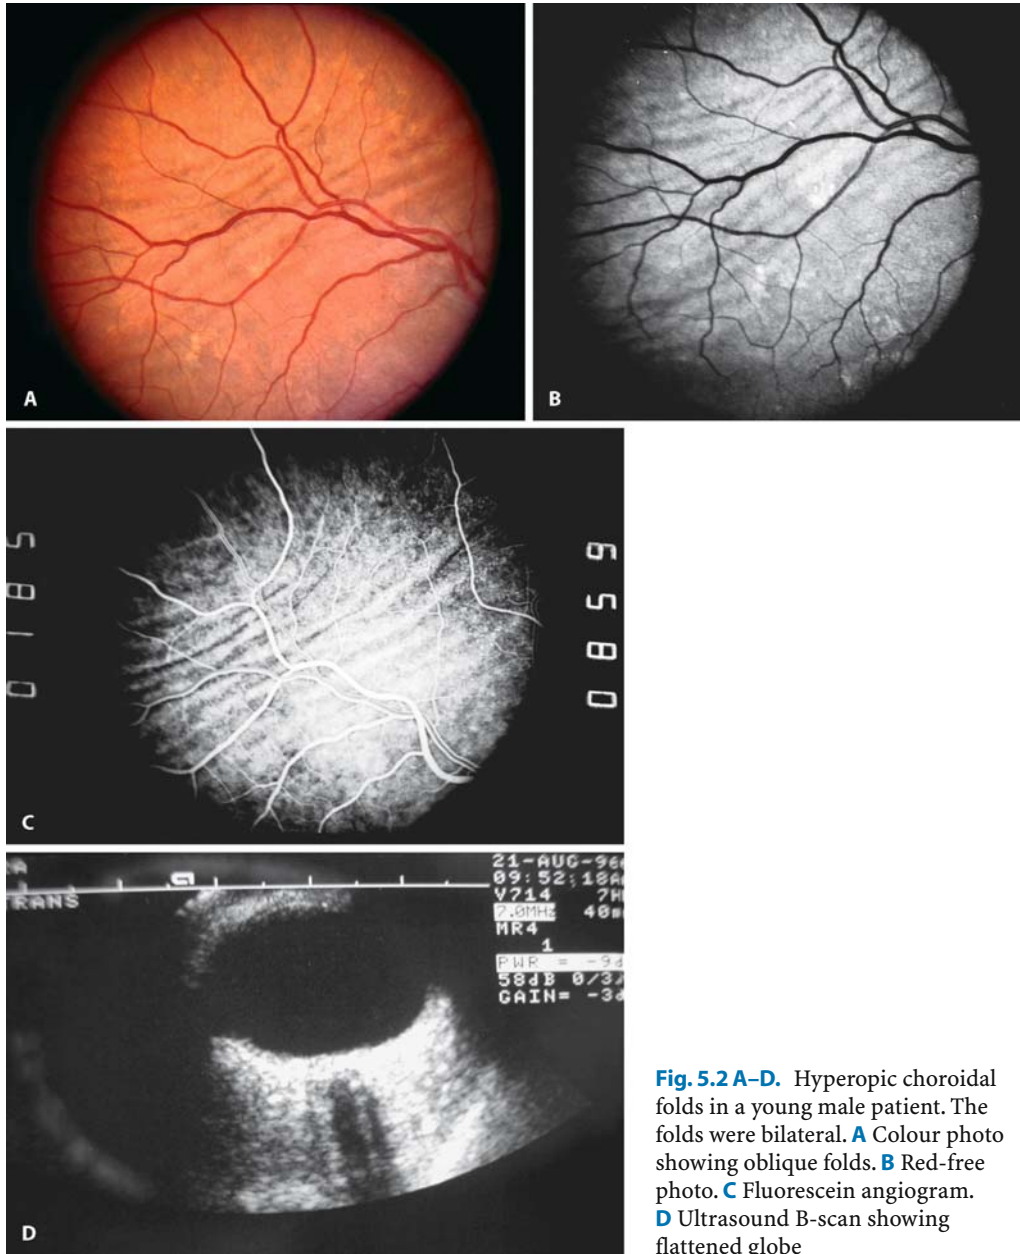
A–D. Hyperopic choroidal folds in a young male patient. The folds were bilateral. A Colour photo showing oblique folds. B Red-free photo. C Fluorescein angiogram. D Ultrasound B-scan showing flattened globe
